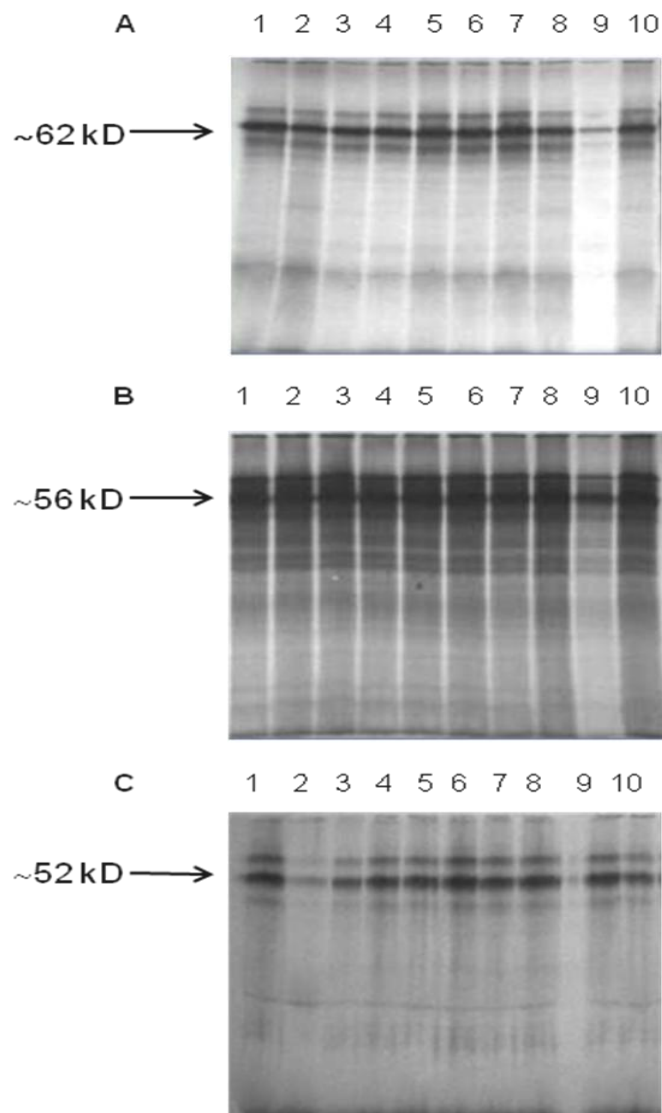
Polypeptides generated for sections of *BRCA1* exon 11. The translated polypeptides were separated on a 12% poly-acrylamide gel and exposed overnight to an X-ray. A. Polypeptides of ~62 kD representing fragment 1 of *BRCA1* exon 11. B. Polypeptides of ~56 kD representing fragment 2 of *BRCA1* exon 11. C. Polypeptides of ~52 kD representing fragment 3 of *BRCA1* exon 11. Lanes 1 to 10 within each figure represent amplified DNA fragments for CAM 1979 (lane 1), CAM 1976 (lane 2), CAM 1978 (lane 3), CAM 1989 (lane 4) CAM 2037 (lane 5), CAM 2038 (lane 6), CAM 2027 (lane 7), CAM 2028 (lane 8), CAM 2034 (lane 9) and CAM 2035 (lane 10).
